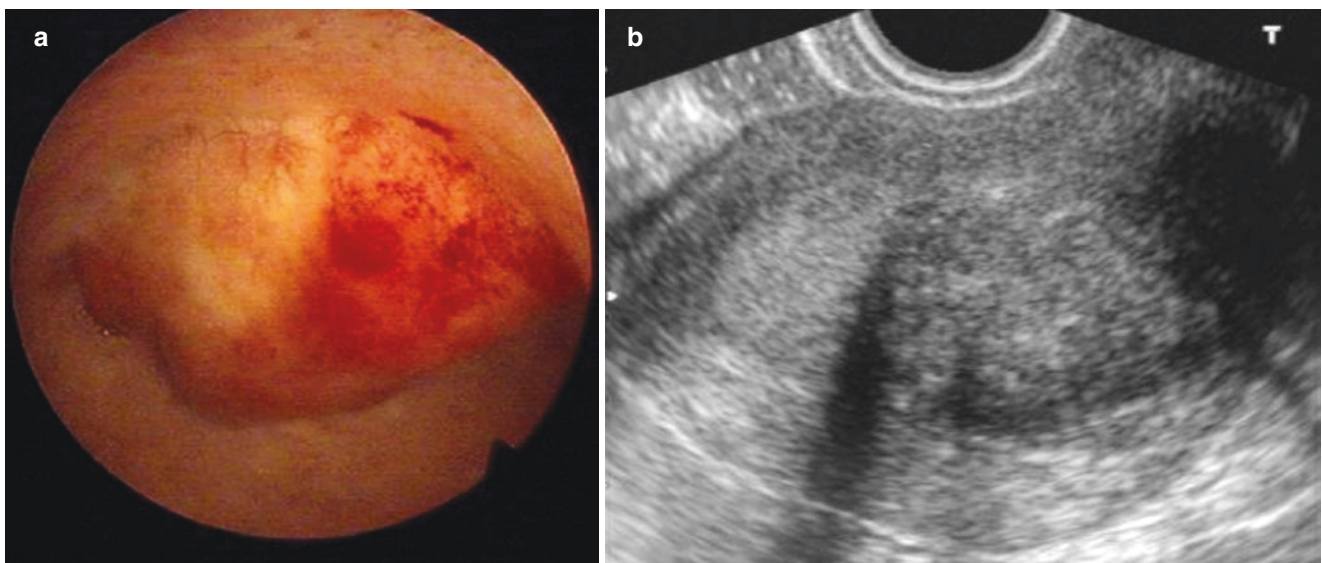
intramural myoma. (a) Hysteroscopy shows the myoma partly extrudes into the uterine cavity. (b) Intramural myoma is displayed by ultrasonography
